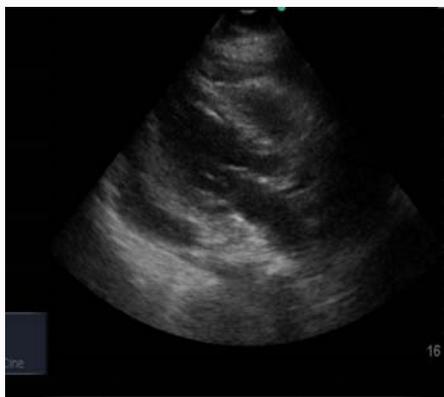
2 D echocardiogram showing moderate pericardial effusion.
